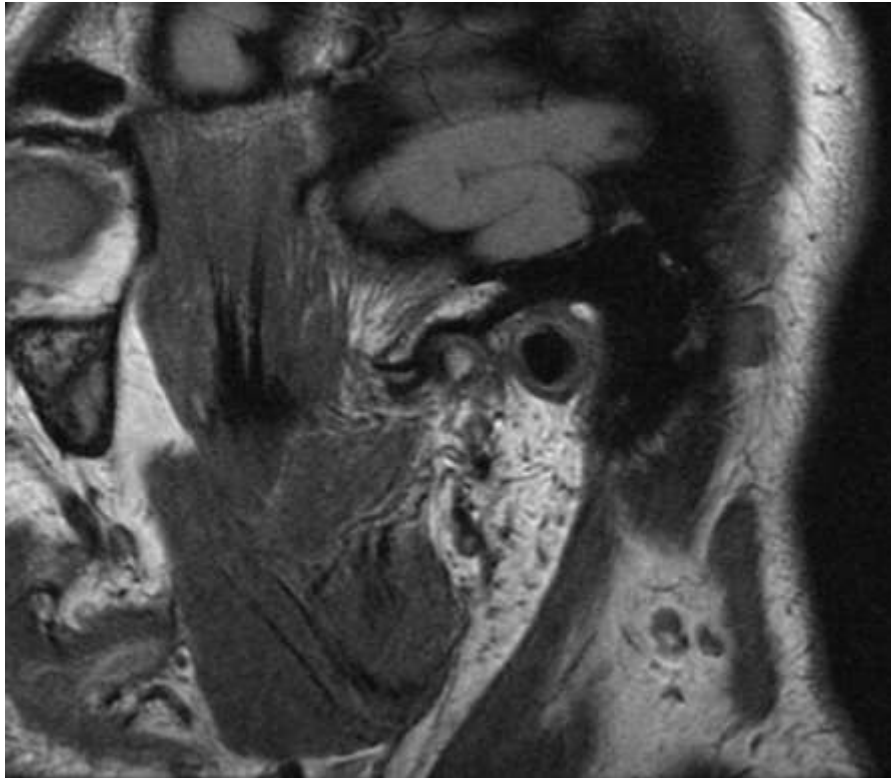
MRI sagittal slice demonstrating missing left parotid gland and associated soft tissues
